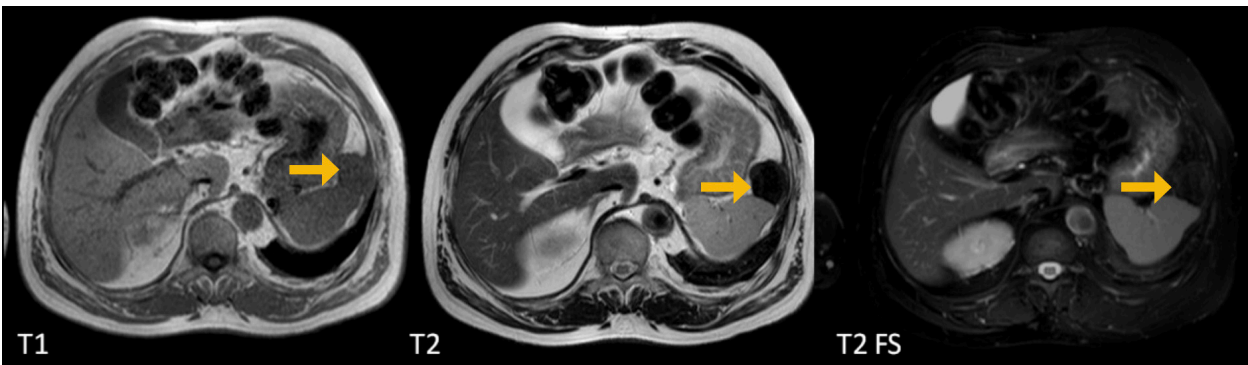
Intraabdominal fibromatosis (mature form) in a 40-year-old female. MR images showing a well-defined intraabdominal mass anterior to the spleen (arrows) with intermediate signal on T1 weighted images and low signal on T2 and T2 FS weighted images.
